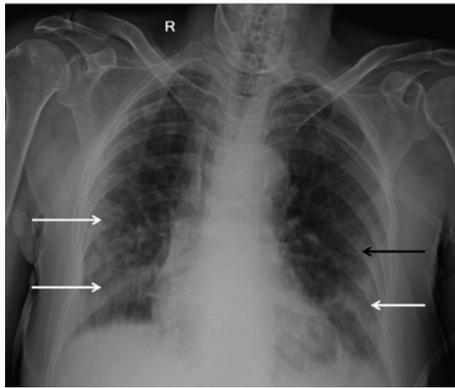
AP chest radiograph of 75-year-old female showing ground-glass opacification in left mid zone (black arrow) with admixture of GGO and consolidation in right mid, right lower and left lower zones (white arrows).
